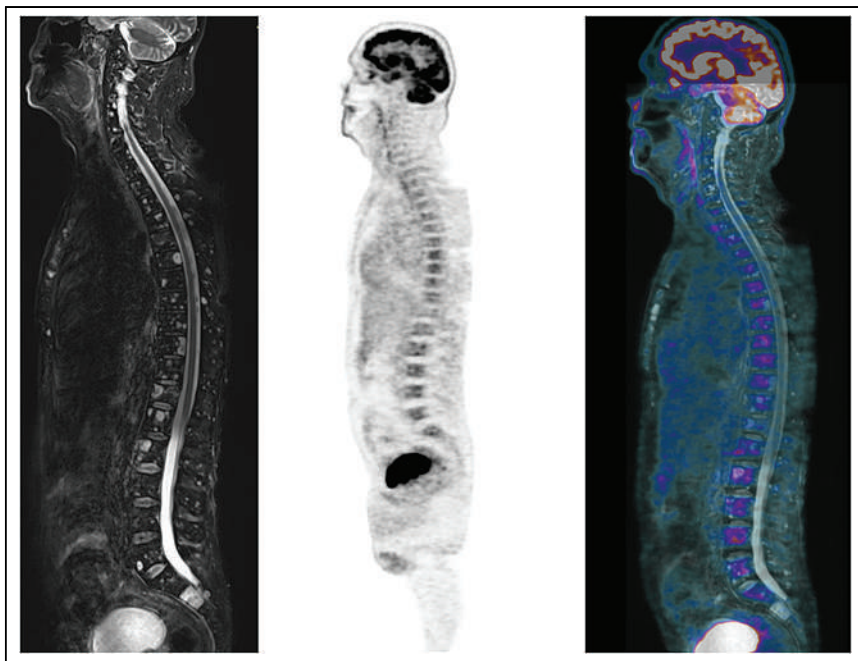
Sagittal T2-weighted short- τ inversion recovery MR (left), PET (middle), and PET/MR (right) images of disseminated FLs of spine. There is no evidence of increased ^{18}F -FDG avidity corresponding to MRI findings.
